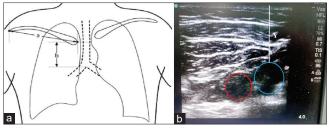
(a) Calculated measurement x = 2/3a + b. (b) Skin to AxV distance on ultrasound
